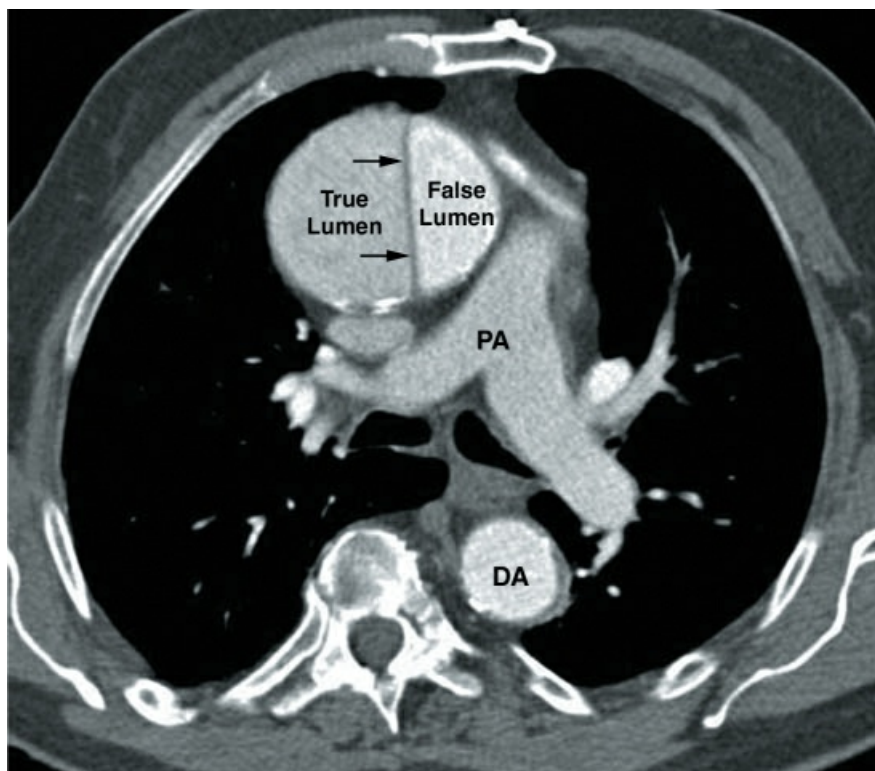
Contrast-enhanced CT image showing an acute dissection in the ascending aorta. The intimal flap that separates the true and false lumens (indicated by the small arrows) distinguishes an aortic dissection from a saccular aneurysm. PA = pulmonary artery, DA = descending aorta.
